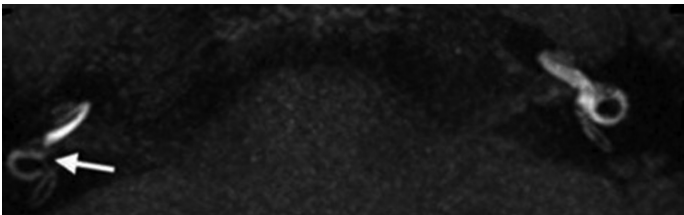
Three-dimensional SPC-IR-FLAIR sequence MIP reconstruction image. The right cochlear duct is small and the vestibular signal is obviously low.
